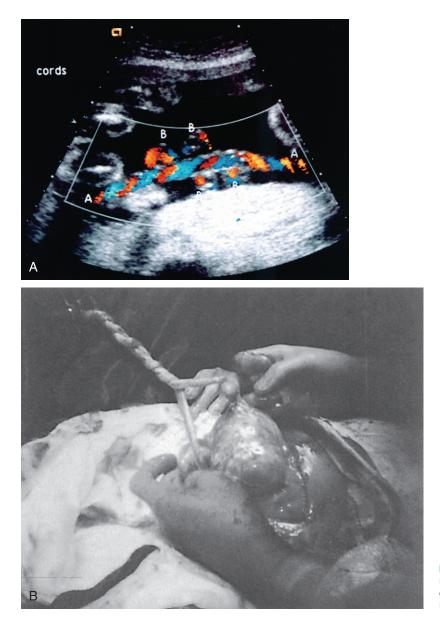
A, Cord entanglement detected by Doppler ultrasound in a monoamniotic twin gestation. B, Entangled cords found during cesarean delivery in a case of monochorionic monoamniotic twins.
